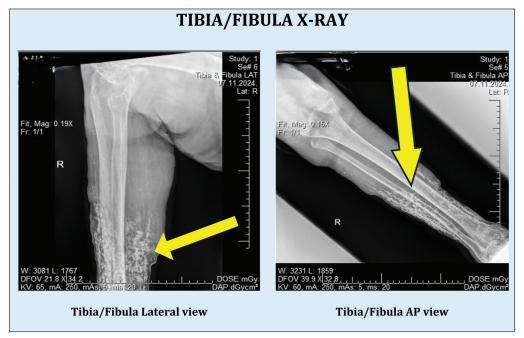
X-ray diagnostic of the right tibia and fibula lateral (LAT) and anterior posterior views. Yellow arrow showing diffuse soft tissue calcifications embedded within muscles of the soft tissue
